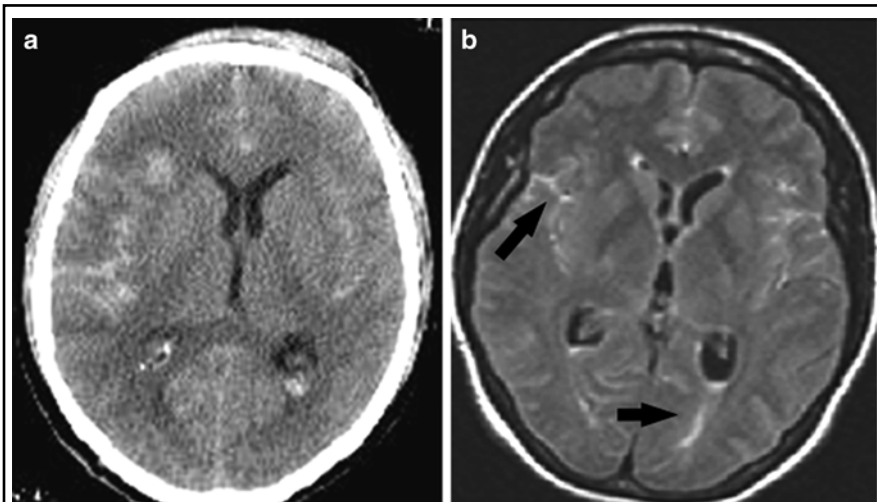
CT AND MRI OF SUBARACHNOID HEMORRHAGE
